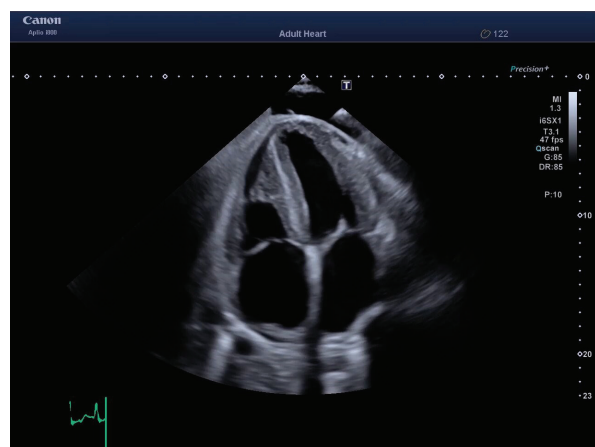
Assessment of cardiac muscle by transthoracic echocardiography
